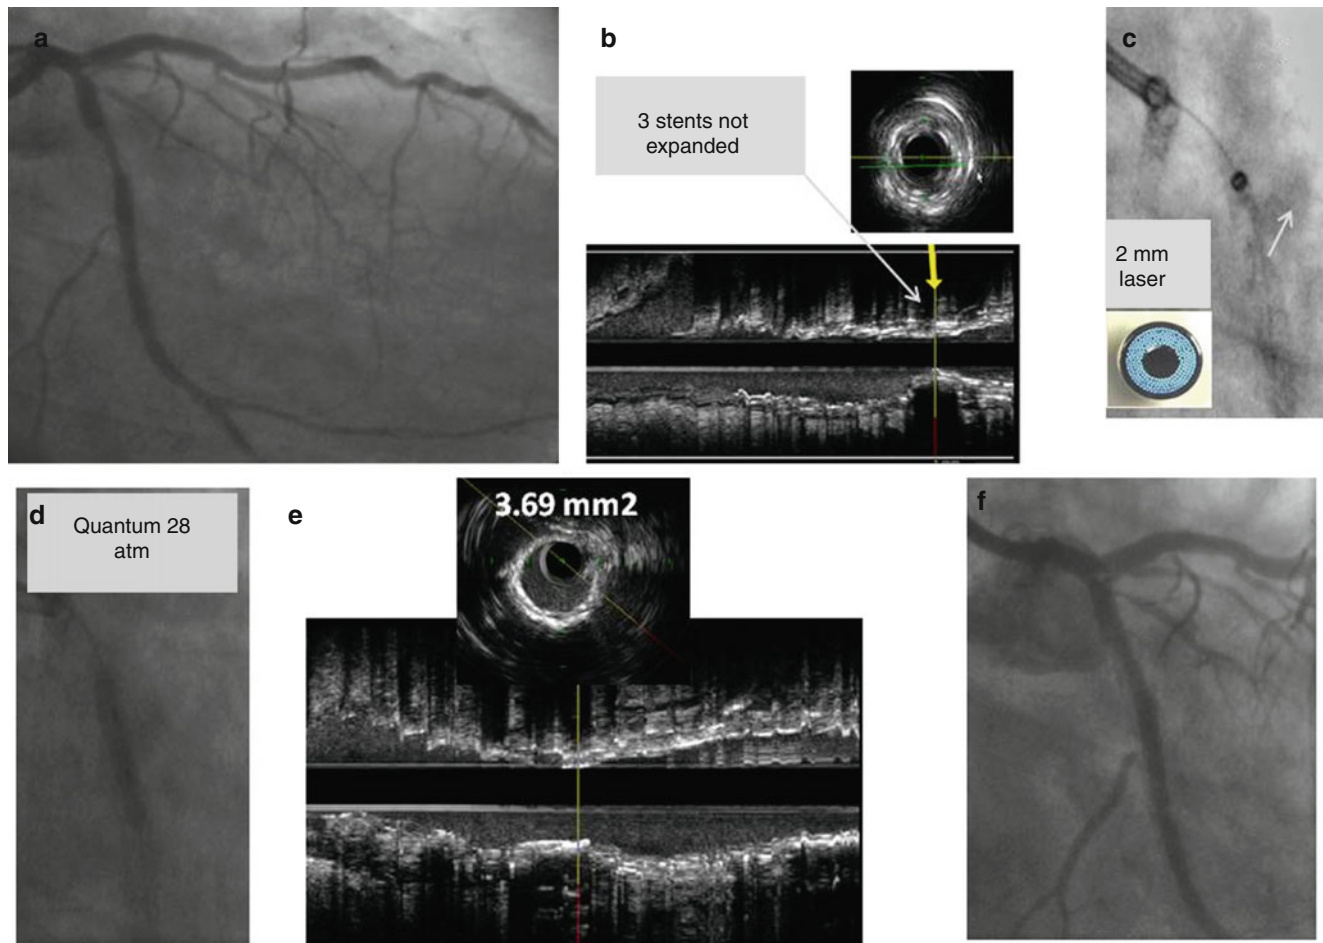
Underexpanded stent with recurrent in-stent restenosis. Coronary angiogram revealed focal ISR in the proximal circumflex artery of the multiple overlapped stents (a). Intravascular ultrasound showed under expanded stents in an area of severe underlying concentric calcification. Minimal luminal area was 1.3 mm² (b). Multiple
